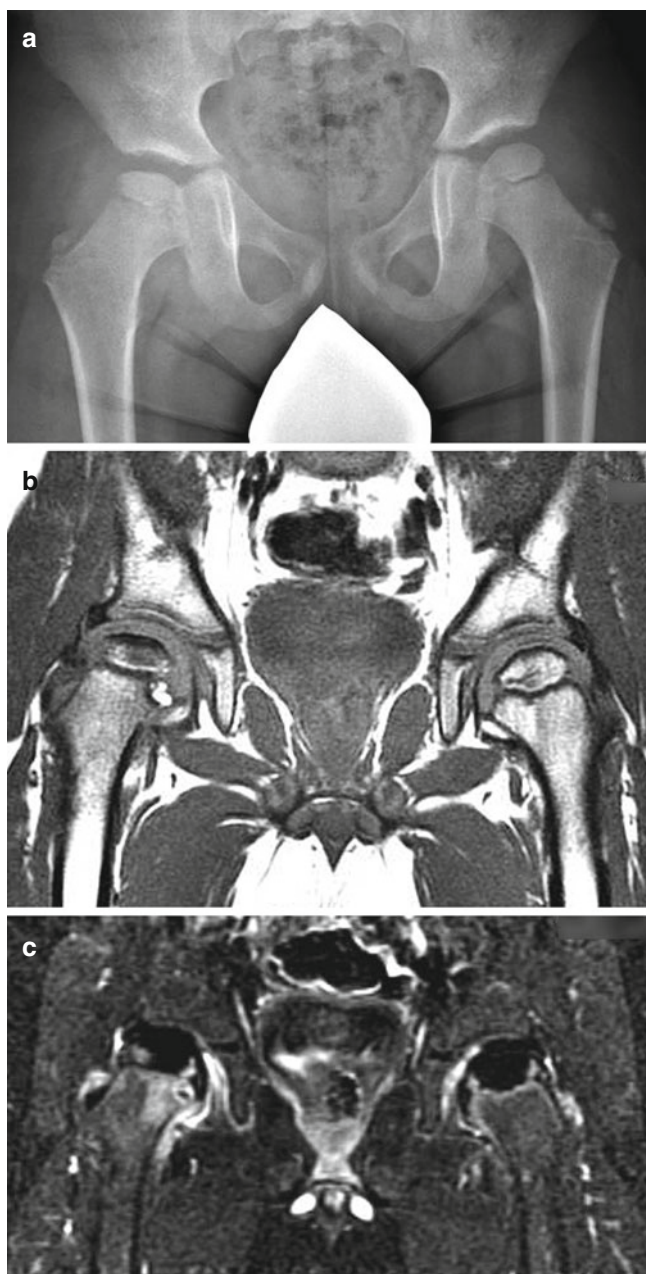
A 5-year-old male complaining of right hip pain for 2 months. (a) AP radiograph shows right femoral head in the initial stage of LCPD with increased radiodensity and slight depression of the superior aspect of the epiphysis. (b) Non-contrast T1 image showing a noticeable signal decrease in the right epiphysis but no notable decrease in the left epiphysis. (c) Contrast-enhanced T1 with subtraction technique showing the loss of blood flow to the right epiphysis and unsuspected loss of blood flow to the left epiphysis not detected on the non-contrast images. This patient became symptomatic on the left side 5 months later and also developed radiographic signs of the initial stage of LCPD on that side
